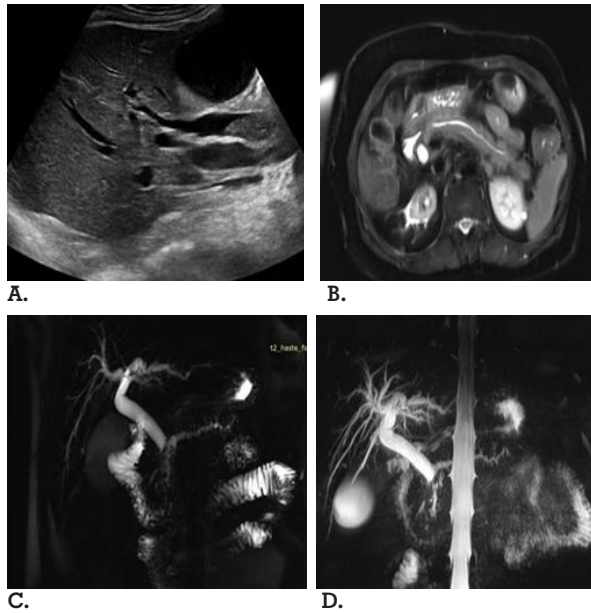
A: Ultrasound image shows IHBRD and dilated CBD with sludge and abrupt tapering in the distal segment of CBD.
